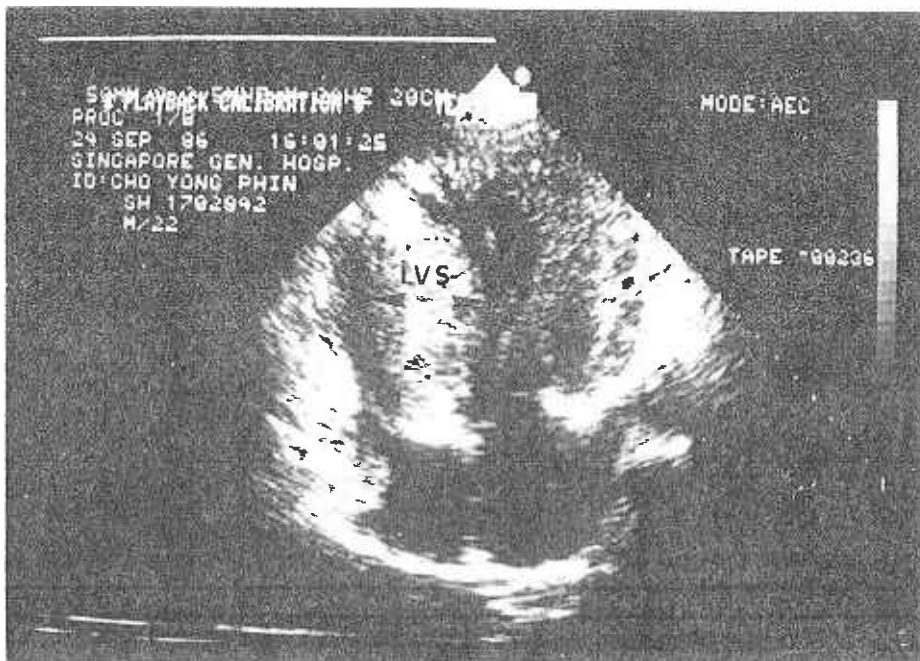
Left parasternal long axis view (2D Echo) shows the thickened interventricular septum (ivs). The ratio of the septum to posterior left ventricular wall is 1.7.
